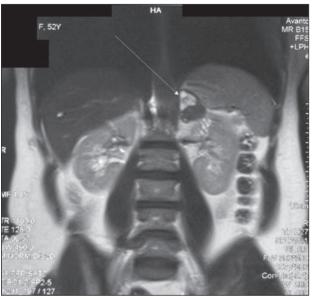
MRI shows left adrenal mass.
